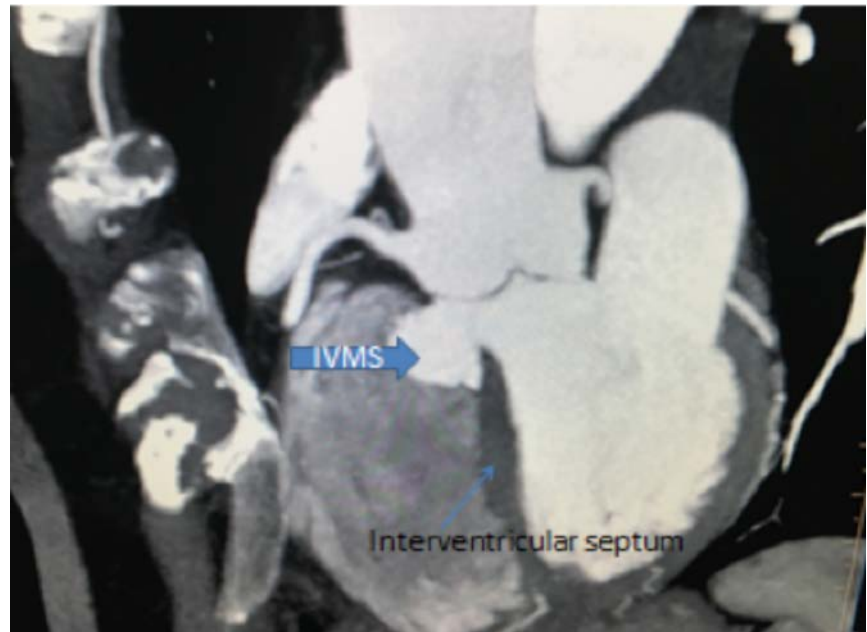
Computed tomographic angiography showing interventricular membranous septal (IVMS) aneurysm (blue arrow): lateral view.
